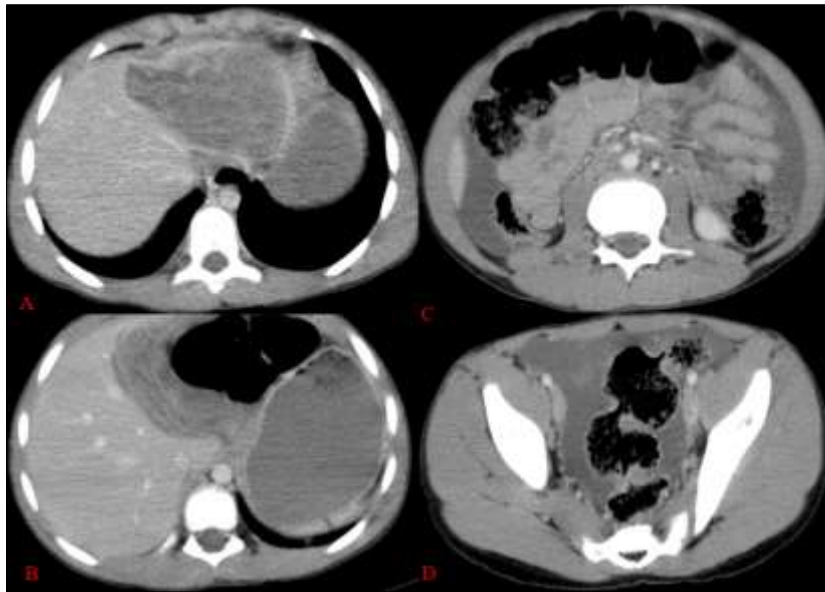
Contrast enhanced CT in portal phase axial sections showing cystic lesion in the left lobe of the liver with a flattened margins (A) containing internal membranes (B) and associated with gross ascites
